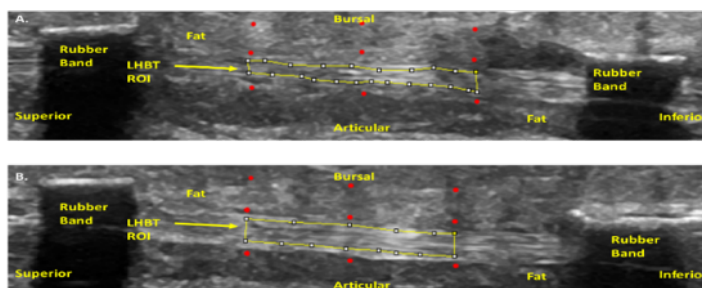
Typical Ultrasound images of LHBT obtained. The ROI for the LHBT is defined by the yellow box in the images. A) Ultrasound image at 15 MPa located within the toe region of the stress strain curve. B) US image at 28 MPa located within the linear region of the stress strain curve.
